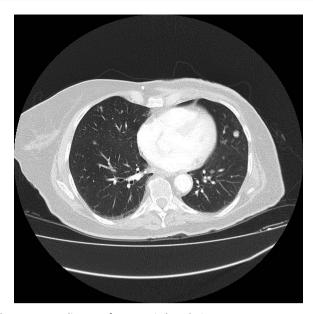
Baseline CT of metastatic lung lesion.
